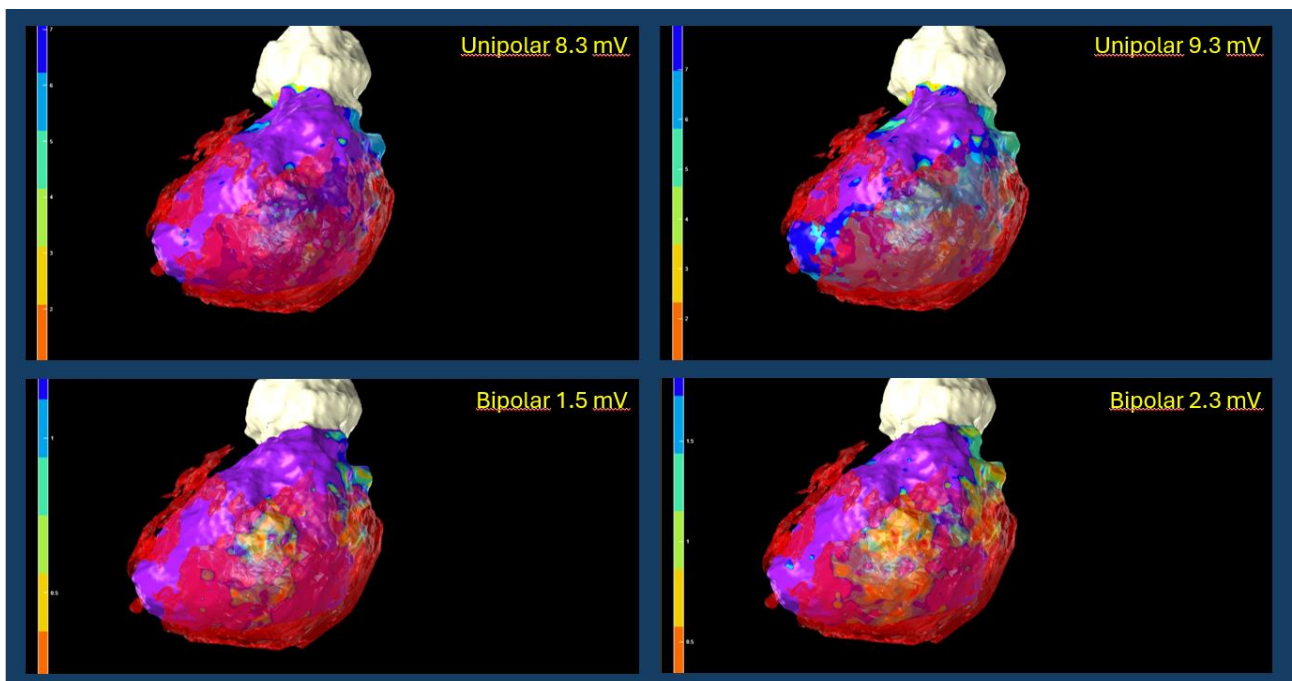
MRI scar and EAM merging. Left panels: Electroanatomic map (using standard voltage cut offs >1.5 mV (BV) and > 8.3 mV (UV) for healthy myocardium. Right Panels: Electroanatomic map (using newly recognised cut offs >2.3 mV (BV) and > 9.3 mV (UV) for healthy myocardium
